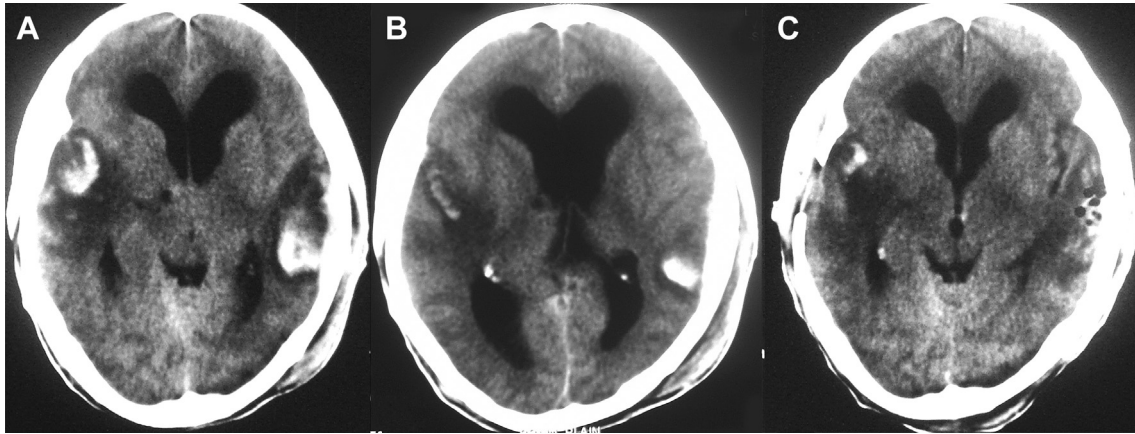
(A and B) CT scan brain plain showing bilateral temporal contusions with peri-lesional edema and mass effect with obliteration of the third ventricle, (C) Follow up scan after 12 h of surgery showing adequate decompression of the contusions, opening up of the third ventricle and visualization of the sylvian cisterns (compare with A).
